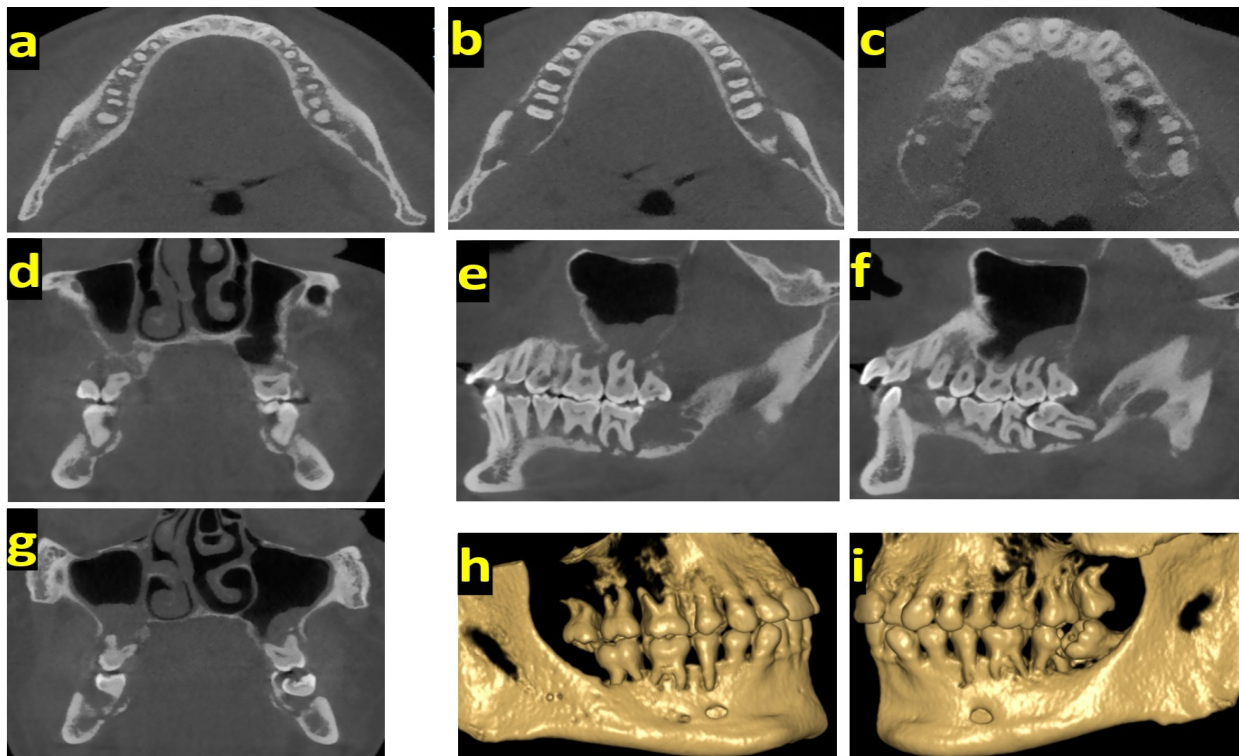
Axial (a, b, c), coronal (d, g), para-sagittal (e: right, f: left) and three-dimensional reconstruction images (h: right, i: left) of cone-beam computed tomography images shows ill-defined destructive radiolucencies on mandibular and maxillary molar regions. Vestibule and oral cortex thinning-destruction, periodontal space widenings of the bilateral mandibular premolar and molar teeth are seen on the axial slices. Destruction of the bilateral maxillary sinus floor is shown on the coronal slices.
